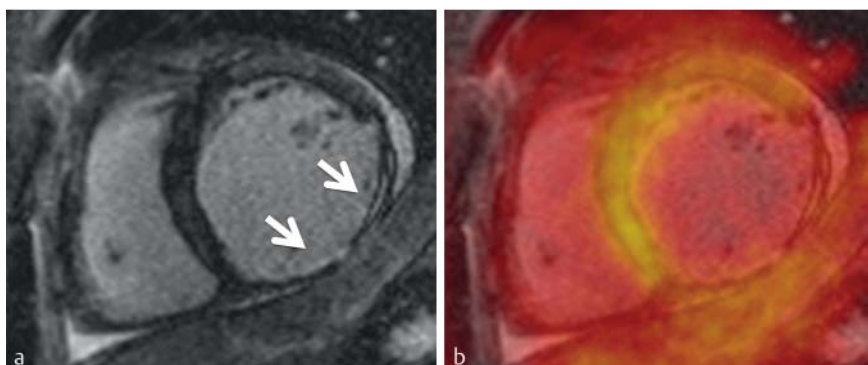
Simultaneous FDG PET/MRI examination in a 55-year-old patient with coronary heart disease and older myocardial scar in the right perfusion region of the right coronary artery. The left short axis image using late gadolinium enhancement shows the extended scar in the posterior wall (a, arrows). Fusion with the PET examination performed in parallel b shows significantly reduced glucose utilization in the region of the myocardial scar.
